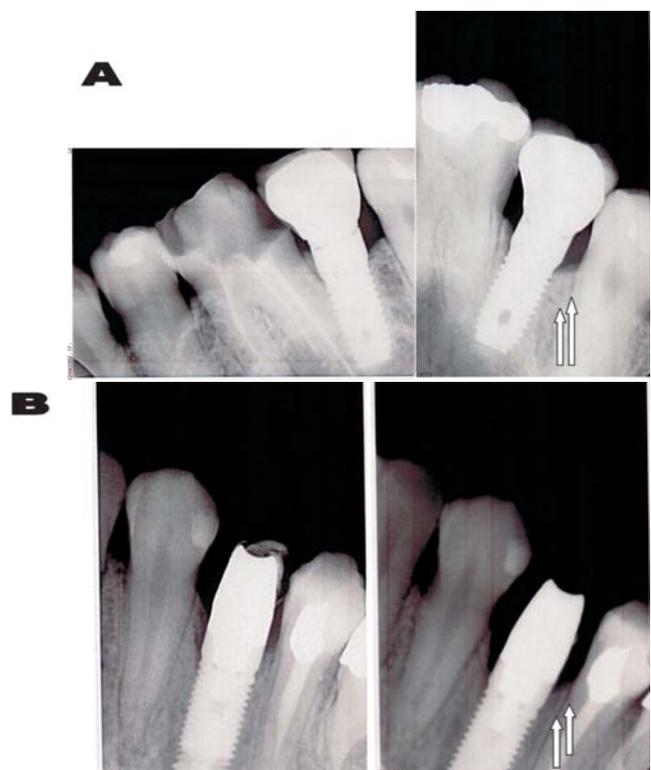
BTLock implant in clinical practice. Radiographs of BTLock implants in area 37 (A) and 44 (B) at the day of insertion (left), and 2 years after loading (right). The implants are clinically healthy and it is possible to observe a very good osseointegration of implants without any bone loss during the time (arrows)
